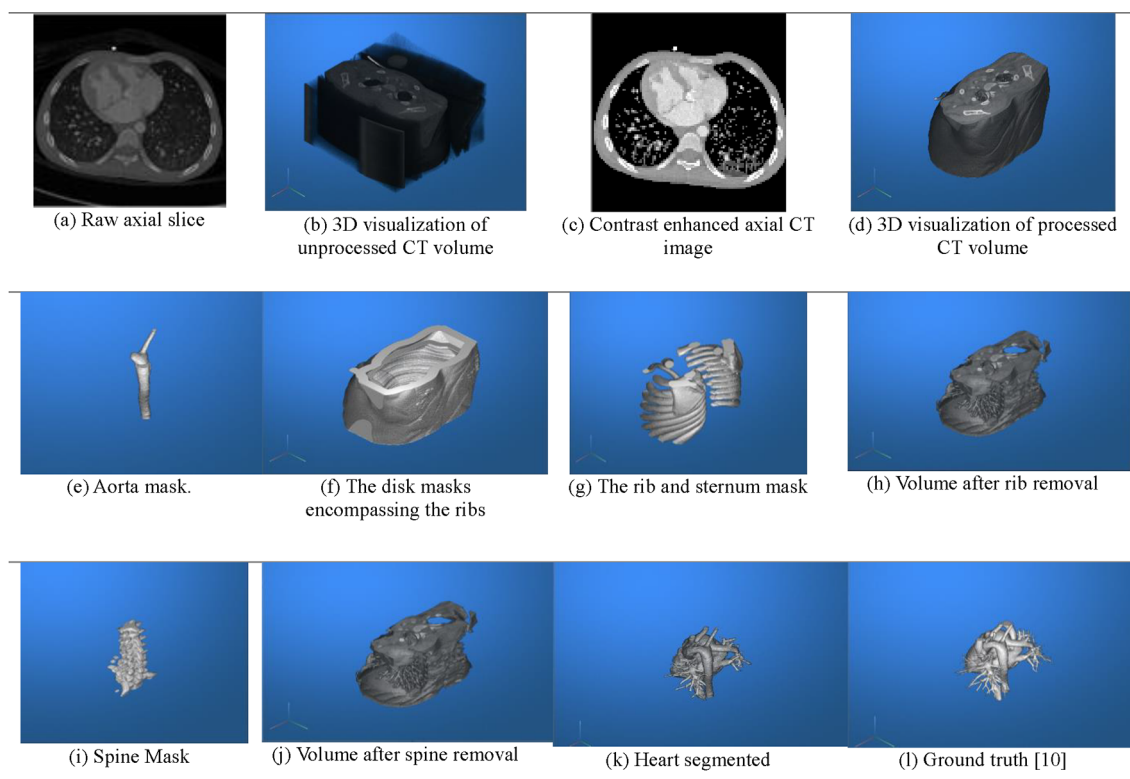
The input axial CT images, intermediate and final results of segmentation
